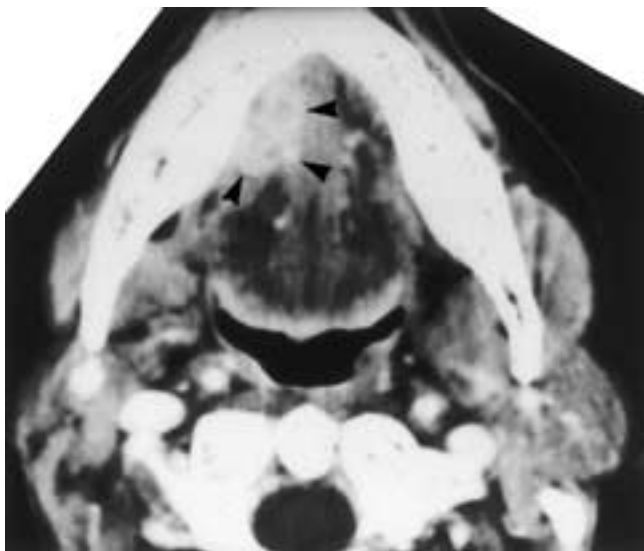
Adenoid cystic carcinoma of the right sublingual gland. Axial contrast-enhanced CT scan reveals an enhancing mass in the anterior aspect of the right tongue obliterating the normally fat-filled right sublingual space (*arrowheads*). On the basis of imaging characteristics, this lesion cannot be distinguished from SCCa originating within the floor of the mouth.
